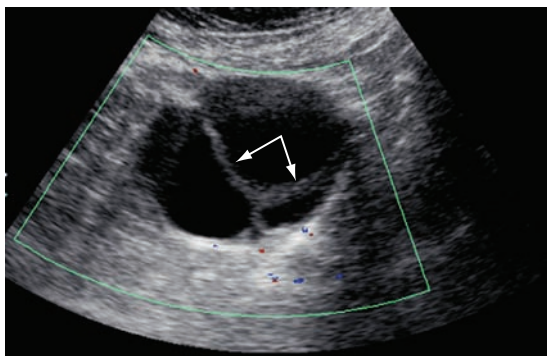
Theca lutein cyst. Transabdominal image in a patient with a hydatidiform mole demonstrates a theca lutein cyst with internal septations (arrows). There was no flow on color Doppler exam.
